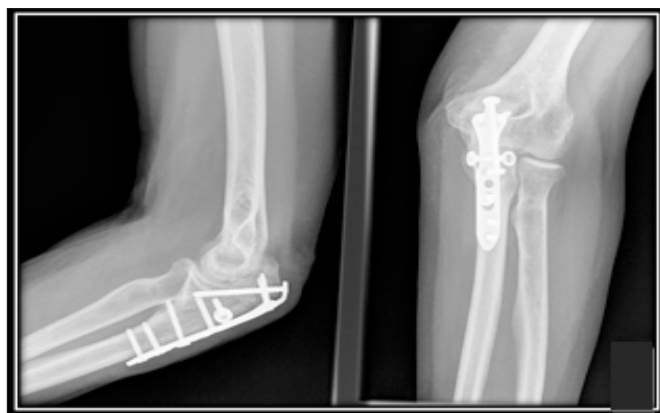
AP and lateral radiographs showing a plate in situ for an olecranon fracture.
